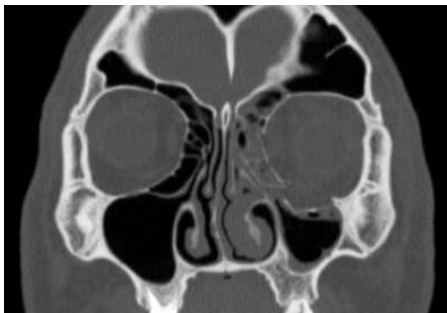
Grade II blowout fractures. (a) Moderate inferior wall fracture with soft tissue prolapse in the coronal CT image. (b) Moderate medial wall fracture with soft tissue prolapse in the axial CT image.
